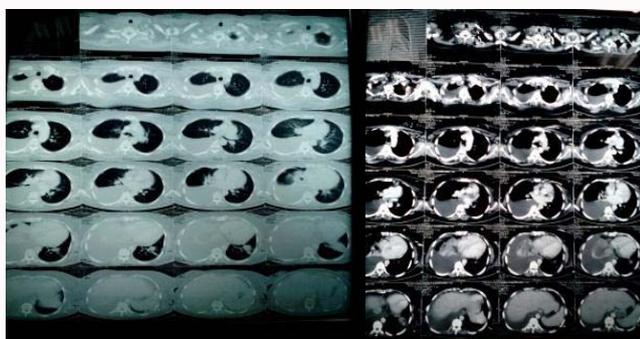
CT chest of female patient revealed enlarged pretracheal and supracaval and aortocaval lymph node and right sided pleural effusion.
